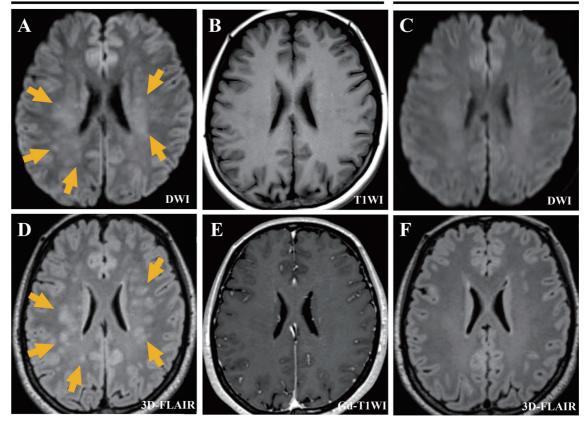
Pre- and post-treatment brain magnetic resonance imaging (MRI) in Case 1. Brain MRI at admission showed patchy high-intensity areas in the cerebral white matter on diffusion-weighted imaging (DWI) (A) and three-dimensional fluid-attenuated inversion recovery (3D-FLAIR) (D) images, and unenhanced T1weighted native images (B, E). Arrows point to the patchy high-intensity areas in the cerebral white matter. Brain MRI after corticosteroid administration showed reduced high-intensity lesions on DWI and 3D-FLAIR images (C, F).
